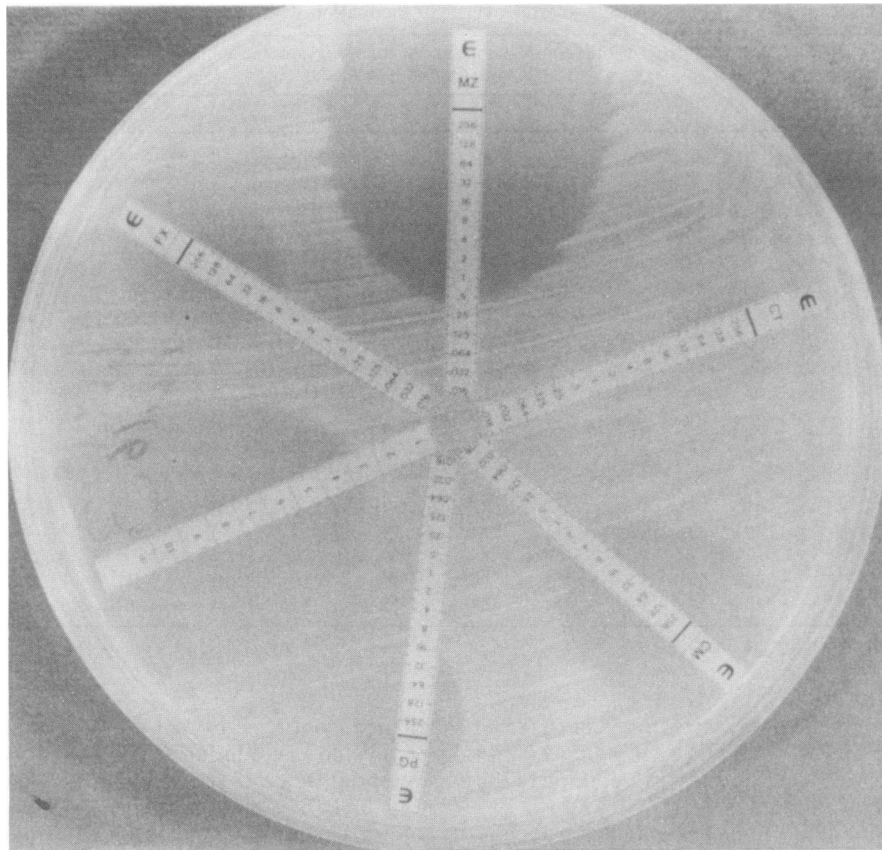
Susceptibility of *B. thetaiotaomicron* to metronidazole (MZ), cefotaxime (CT), clindamycin (CM), penicillin G (PG), imipenem (IP), and cefoxitin (CX) determined by the E test.
